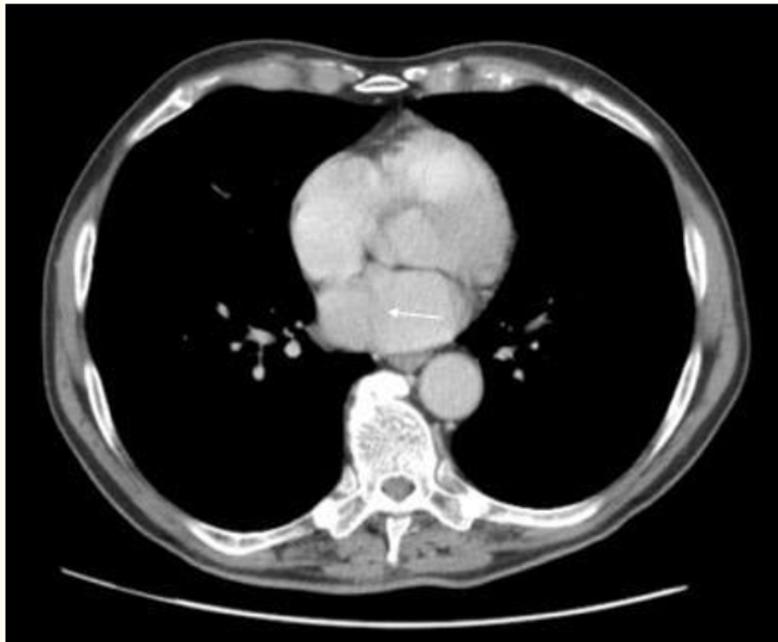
Case 1. Cardiac CT scan. Fibromuscular septum separating left atrium into two chambers.
